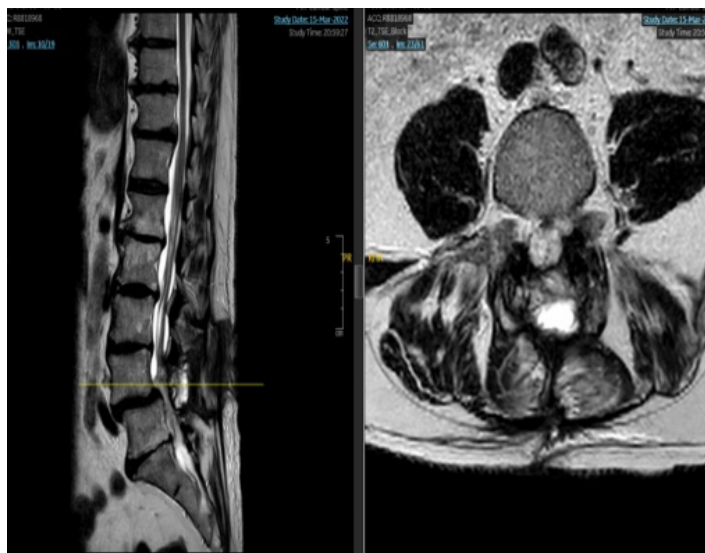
In contrast with the previous post-operative MRI scan, we can see a more open canal with fluid content which represents filling of CSF and now Arachnoiditis is more visible.
